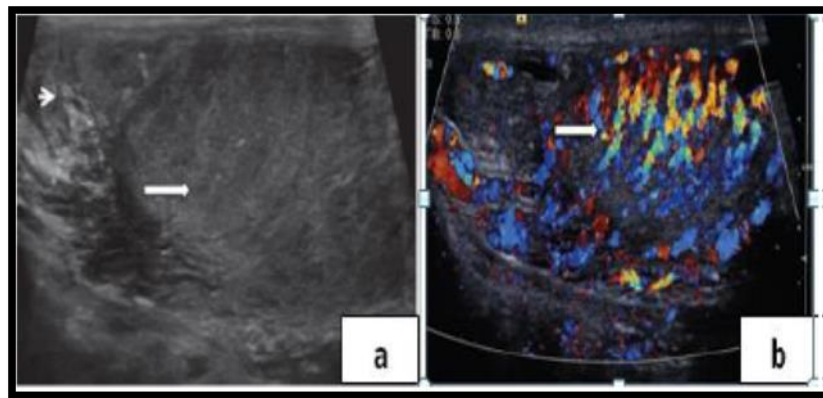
shows the Orchitis. (a) Longitudinal ultrasound of the testis demonstrates patchy heterogeneous reflectivity within the testis (long arrow) and enlargement of the epididymis (short arrow). (b) There is marked increase in vascularity within the testis on color Doppler ultrasound (arrow)(Cook and Dewbury, 2000).
